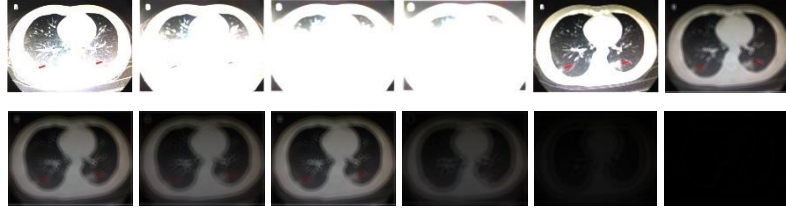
Results of CT image convolving with the 12 filters in the bottom row of Figure 1 (LM37 through LM48)
